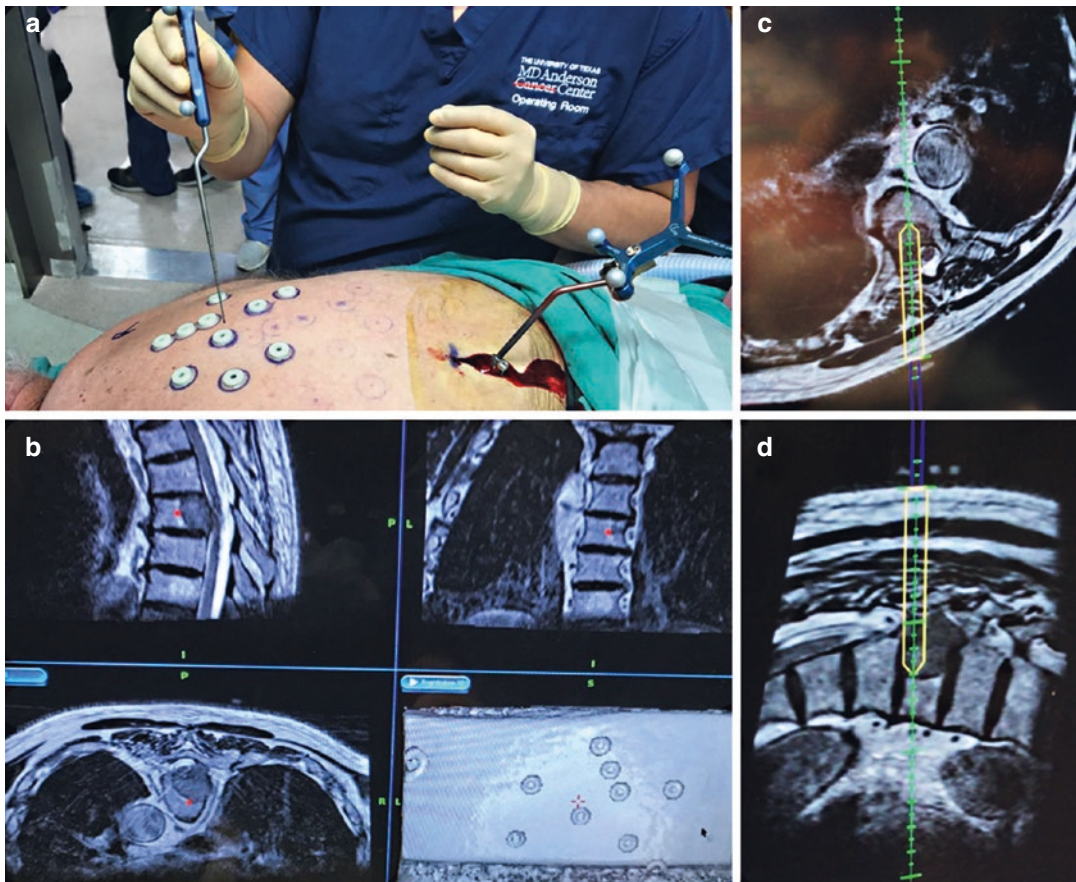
(a) Sterile reference array is attached to the clamp, maintain local sterile conditions. Non-sterile probe is used to perform surface matching of fiducials. (b) MRI 1 mm axial cuts are obtained and transferred to the standard navigation system for surface registration. (c) T2
